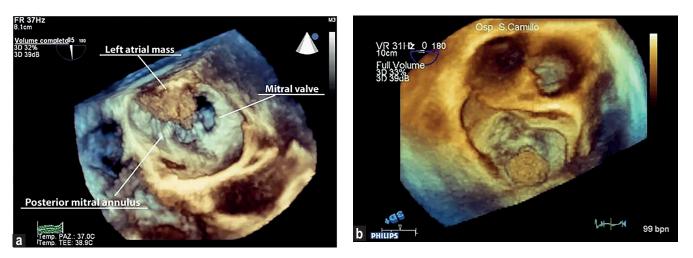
Real-time three-dimensional (3D) echocardiography using a surgical view of the left atrium. The myxoma was demonstrated to be located near the posterior mitral annulus with a diameter of 2.5  $\times$  2 cm [20]
